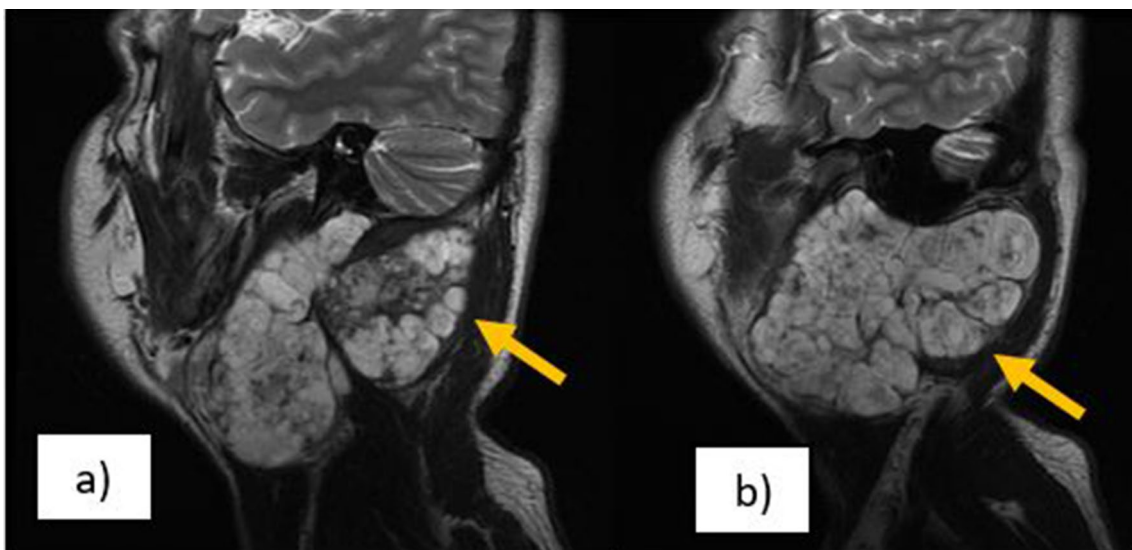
a, b MRI sagittal with contrast mass centred in parotid extending to C1–C2 transverse process
